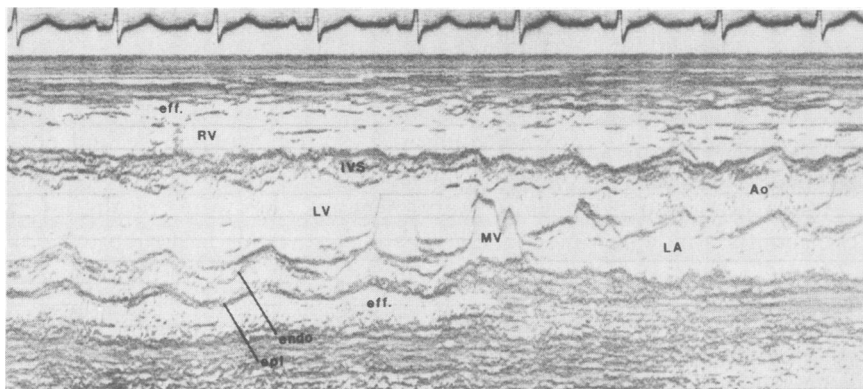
Echocardiogram in case 2 showing pericardial effusion. Note obliteration of the effusion as the echo beam is swept cephalad toward the left atrium (left to right). Ao = aorta; eff = effusion; endo = endocardium; epi = epicardium; IVS = intraventricular septum; LA = left atrium; LV = left ventricle; MV = mitral valve; RV = right ventricle.
